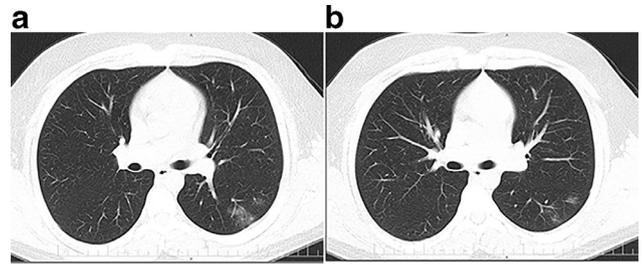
A 14-year-old boy who presented with fever, malaise, and cough for a few days. CT images show small subpleural ground-glass opacifications (GGO) in the left lower lobe.
